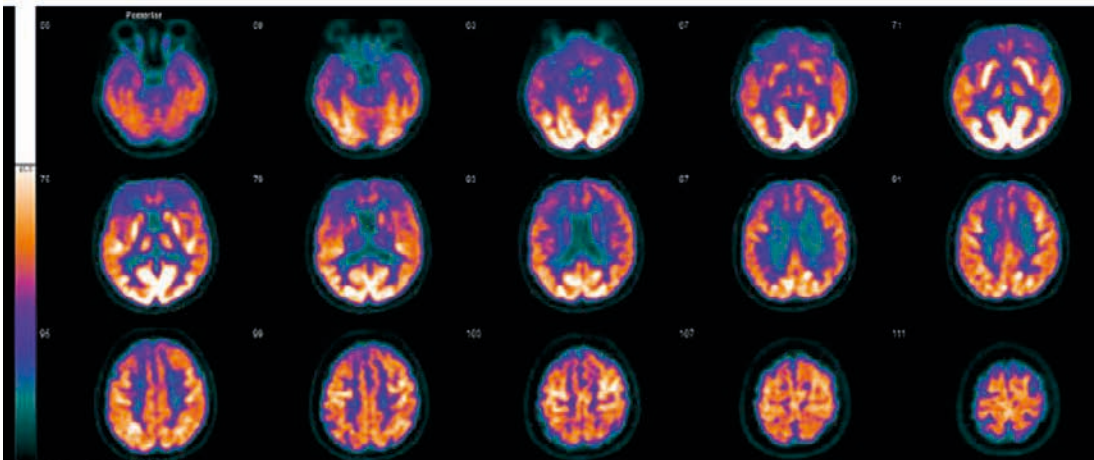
Typical frontal hypoperfusion in FDG-PET.
